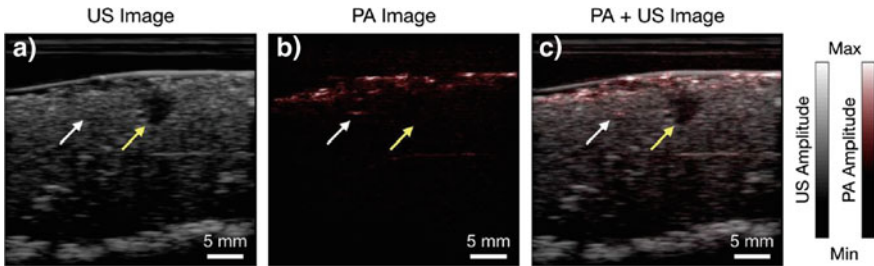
Single frames of ultrasound (US), photoacoustic (PA), and merged US and PA images acquired from a human placenta, at one location (a–c). A large blood vessel (yellow arrow) that is visible in the US image was not visible in the PA image. A subsurface structure was visible with PA imaging (white arrow). All the images are displayed on logarithmic scales [Reprinted with permission from 43]
